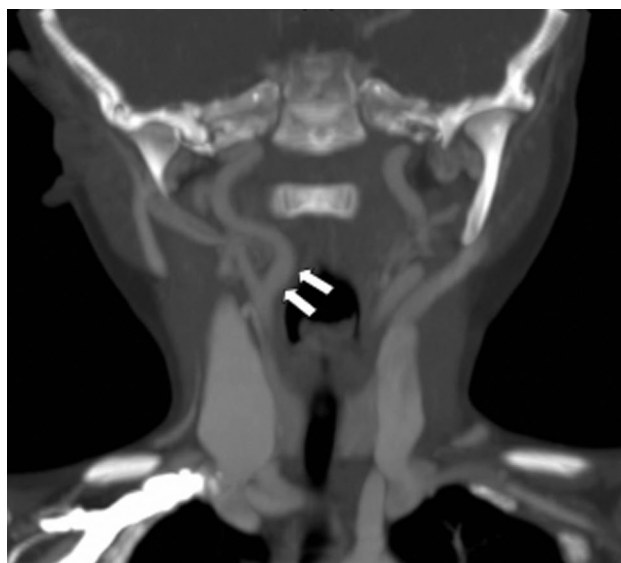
Coronal thick section maximum intensity projection of the raw data obtained during cervical computed tomography angiography. Arrows clearly depict the aberrant course of the right internal carotid artery (double arrows).
